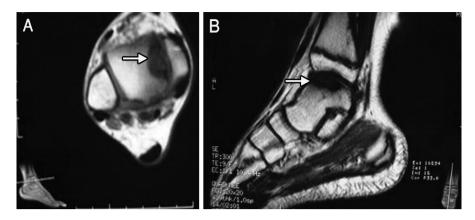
A magnetic resonance imaging (MRI) examination of the ankle joint: A) in horizontal plane, high signal in lateral talus indicates that edema is present, which suggests that cartilage damage is involved (arrow); and B) in sagittal, anterior edema of the talus is obvious.
